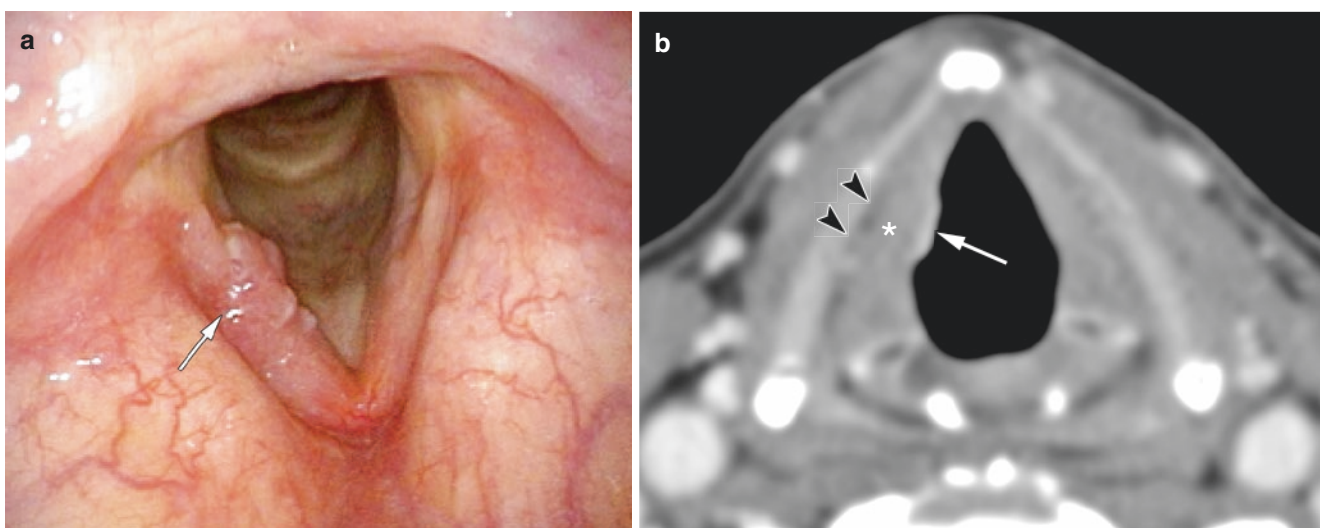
Early glottic cancer (T1a) treated by radiotherapy. (a) Small polypoid clinical T1a lesion of the right vocal cord was observed on laryngoscopy. Axial contrast-enhanced CT (b) also demonstrated T1a
